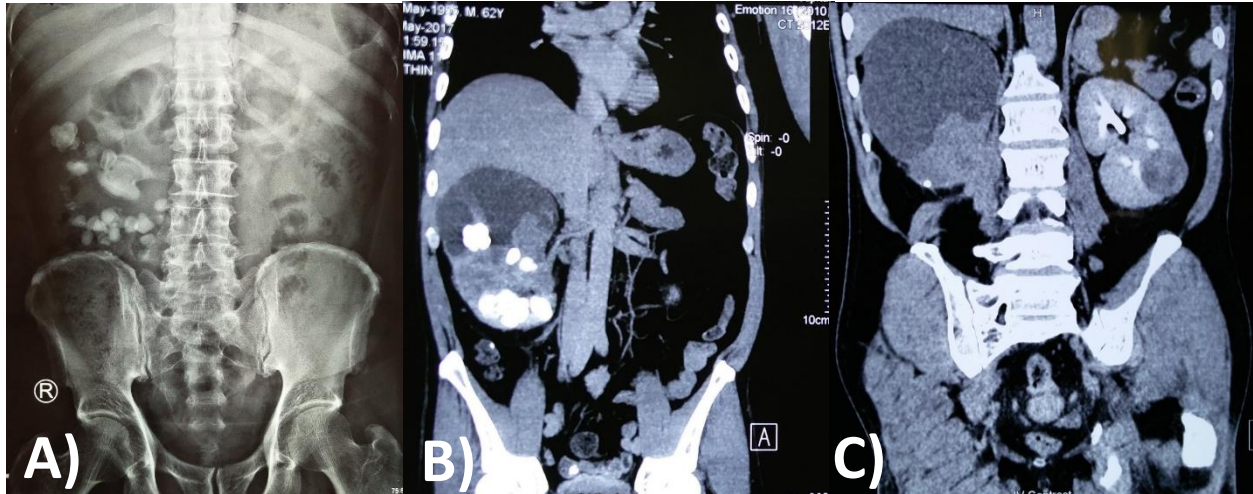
Pre-operative images, A) Plain X-ray Kidney Ureter Bladder (KUB) showing multiple right renal stones, B) Computed tomography (CT) Abdomen showing gross hydronephrosis of upper pole, with mildly enhancing interpolar parenchyma, C) Computed tomography (CT) Abdomen showing left RCC
